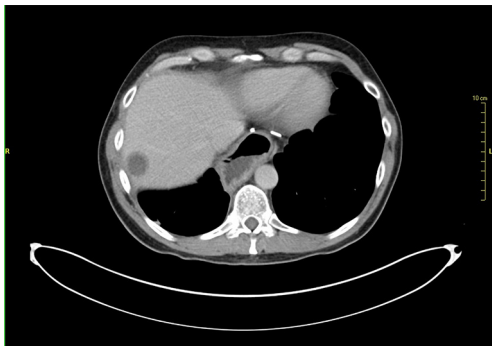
Contrast-enhanced computed tomography during adjuvant treatment with imatinib showing the appearance of a liver metastasis.
